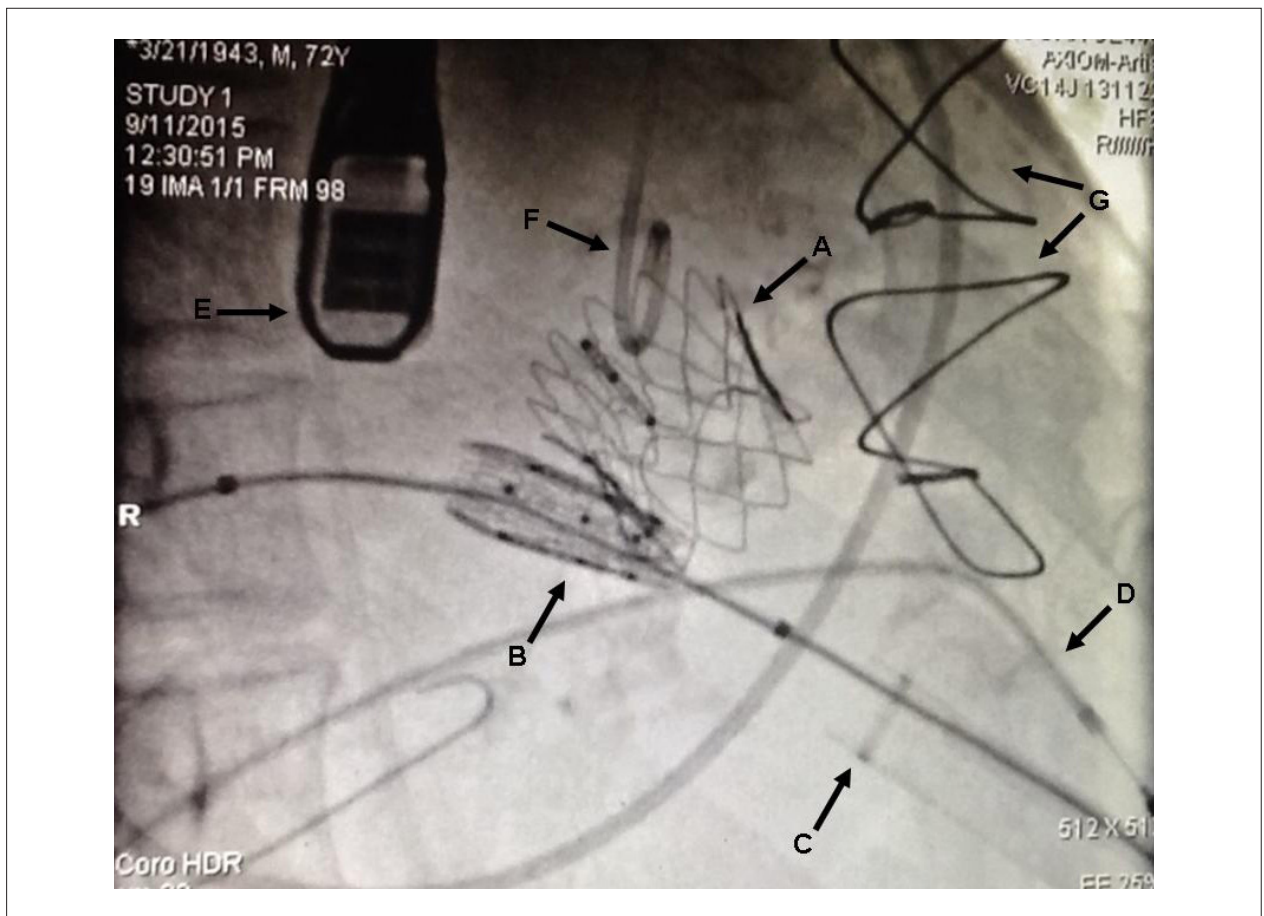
Radioscopy image showing Inovare-Braile bioprosthesis in aortic position no. 28 already implanted (A) and in mitral position no. 30, immediately after the implant (B). The sheath with guidewire for implantation of the mitral prosthesis (C), transvenous pacemaker electrode (D), transducer of the transesophageal echocardiography (E), pigtail catheter in the ascending aorta (F) and prior sternotomy wires (G) are observed.
